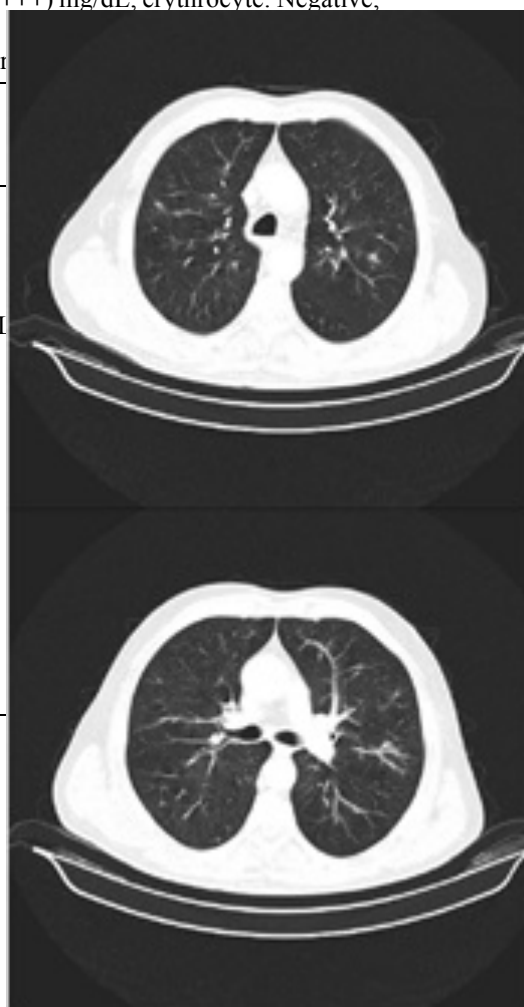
Neck-thorax-abdominal CT
